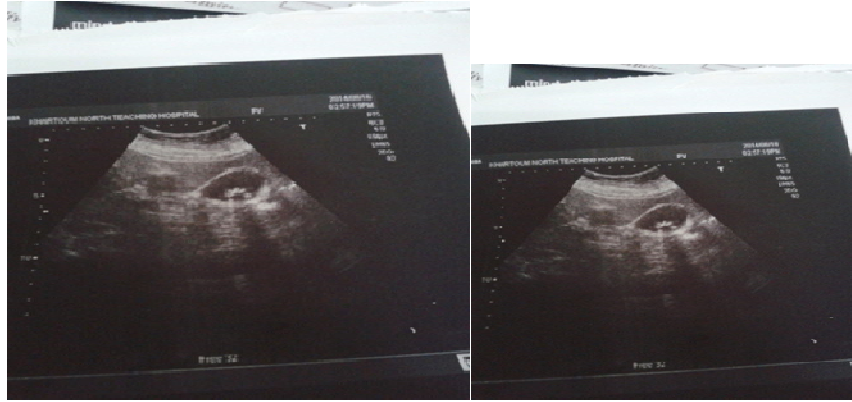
Ultrasound image of 39 years female showing multiple Gallbladder stones.
